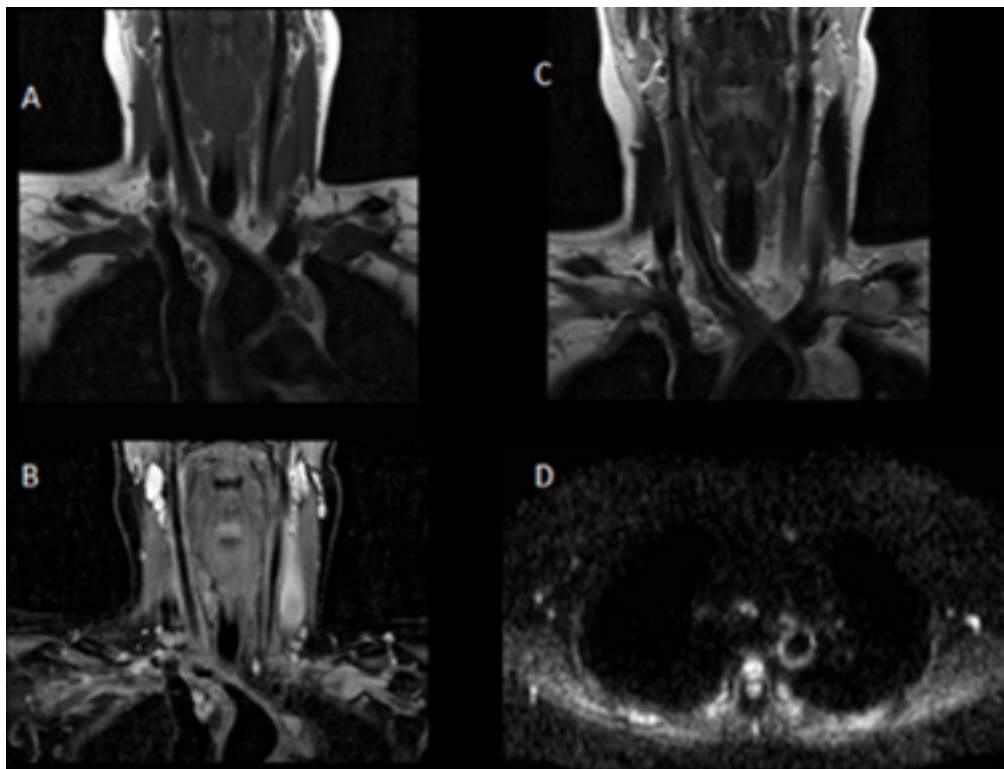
Magnetic resonance imaging. A. T1 sequence, coronal view. B. STIR sequence, coronal view. C. T2 sequence, coronal view. D. Axial diffusion-weighted image. The images show mural thickening of the aortic arch, both subclavian arteries and common carotid arteries in T1 and T2 sequences (A and C), edema of the artery wall and perivascular soft tissue in STIR and T2 sequences (B and C), and increased signal in diffusion-weighted image (D) in the thoracic aorta, suggestive of inflammation.
